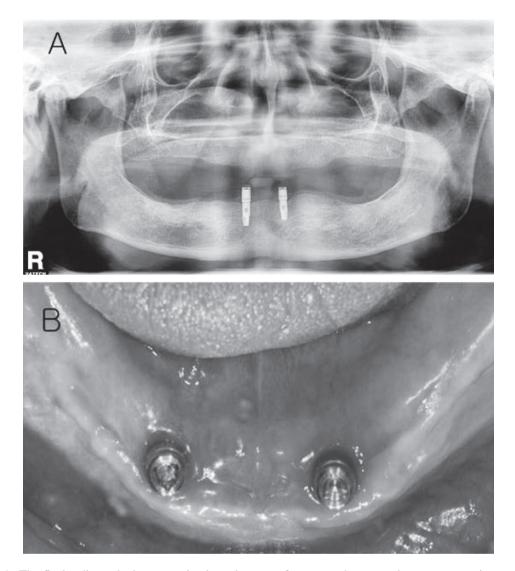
A. The final radiograph shows two implant placement for an overdenture and apparent osseointegration. B. Following implant placement, locator abutments are selected for an abutment finish line of 2 mm above the crest.
